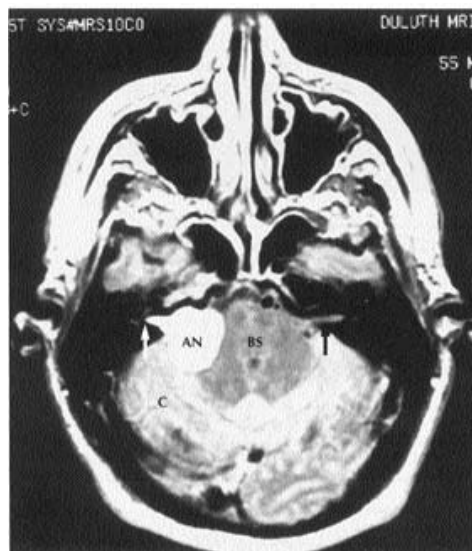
Magnetic resonance image (transverse view) showing acoustic neuroma arising from the vestibulocochlear nerve (arrows). (AN = acoustic neuroma; BS = brain stem; C = cerebellum)
